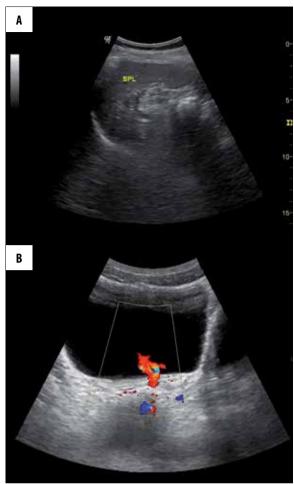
(A) Transverse ultrasound of the left hypochondrium showing absent kidney in the left renal fossa. (SPL — spleen). (B) Color Doppler transverse ultrasound of the urinary bladder showing a jet of urine emerging from the left uretero-vesical junction.
